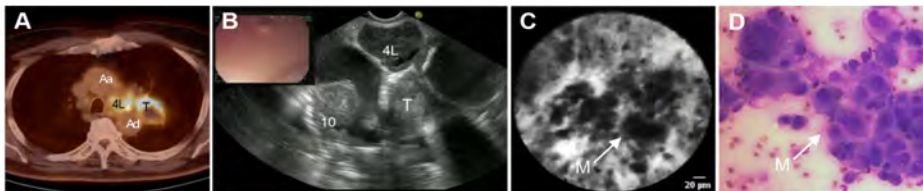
Endosonography guided nCLE of a mediastinal lymph node metastasis of a tumour in the left upper lobe. a PET-CT scan showing fludeoxyglucose-avid lymph node station 4 L, and the primary lung tumour (T). b EUS image showing an enlarged lymph nodes at station 4 L. c Real-time nCLE image of lymph node station 4 L showing large pleomorphic cells and dark clumps recognized as malignant cells (M). d Fine needle aspirate showing malignant cells of squamous cell carcinoma (Wijmans et al. [26]). 10, lymph node station 10 L (left); Aa, ascending aorta; Ad, descending aorta.
